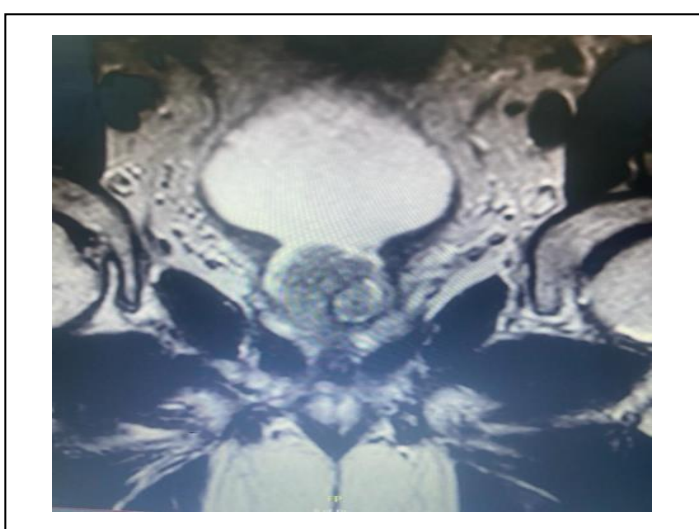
Coronal T2 weighted MRI section.
